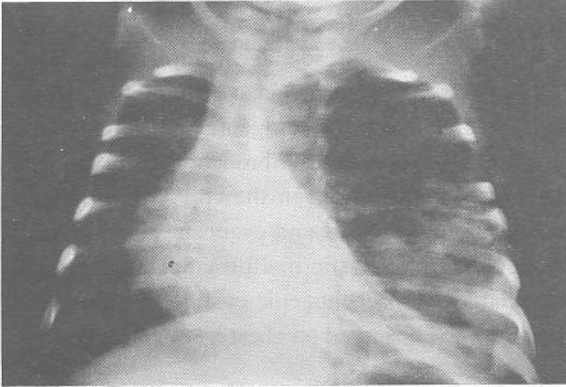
Posteroanterior chest x-ray in case 1. Heart and esophagus deviated to the right, due to the compression of the large air cyst in the left hemithorax.
